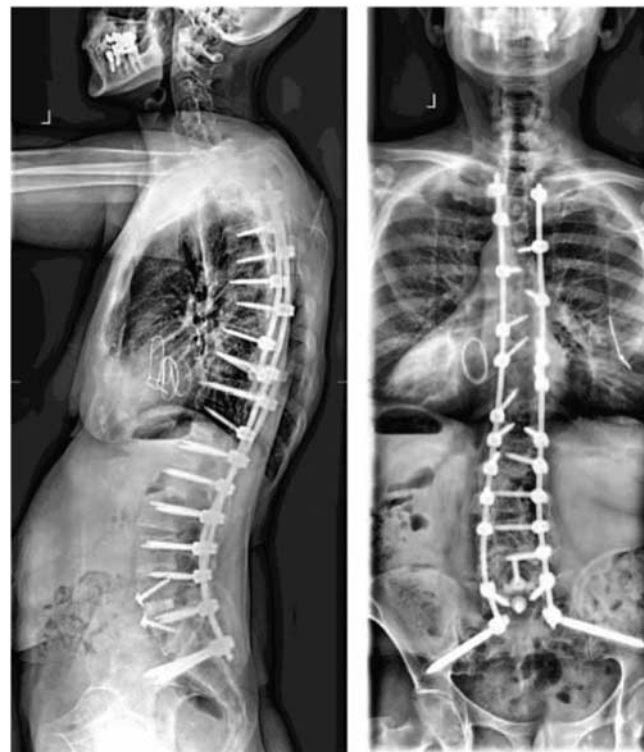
Three years postoperative radiographs demonstrating both lucency around the left S2 iliac screw and a rod fracture on the left above the S1 screw.
